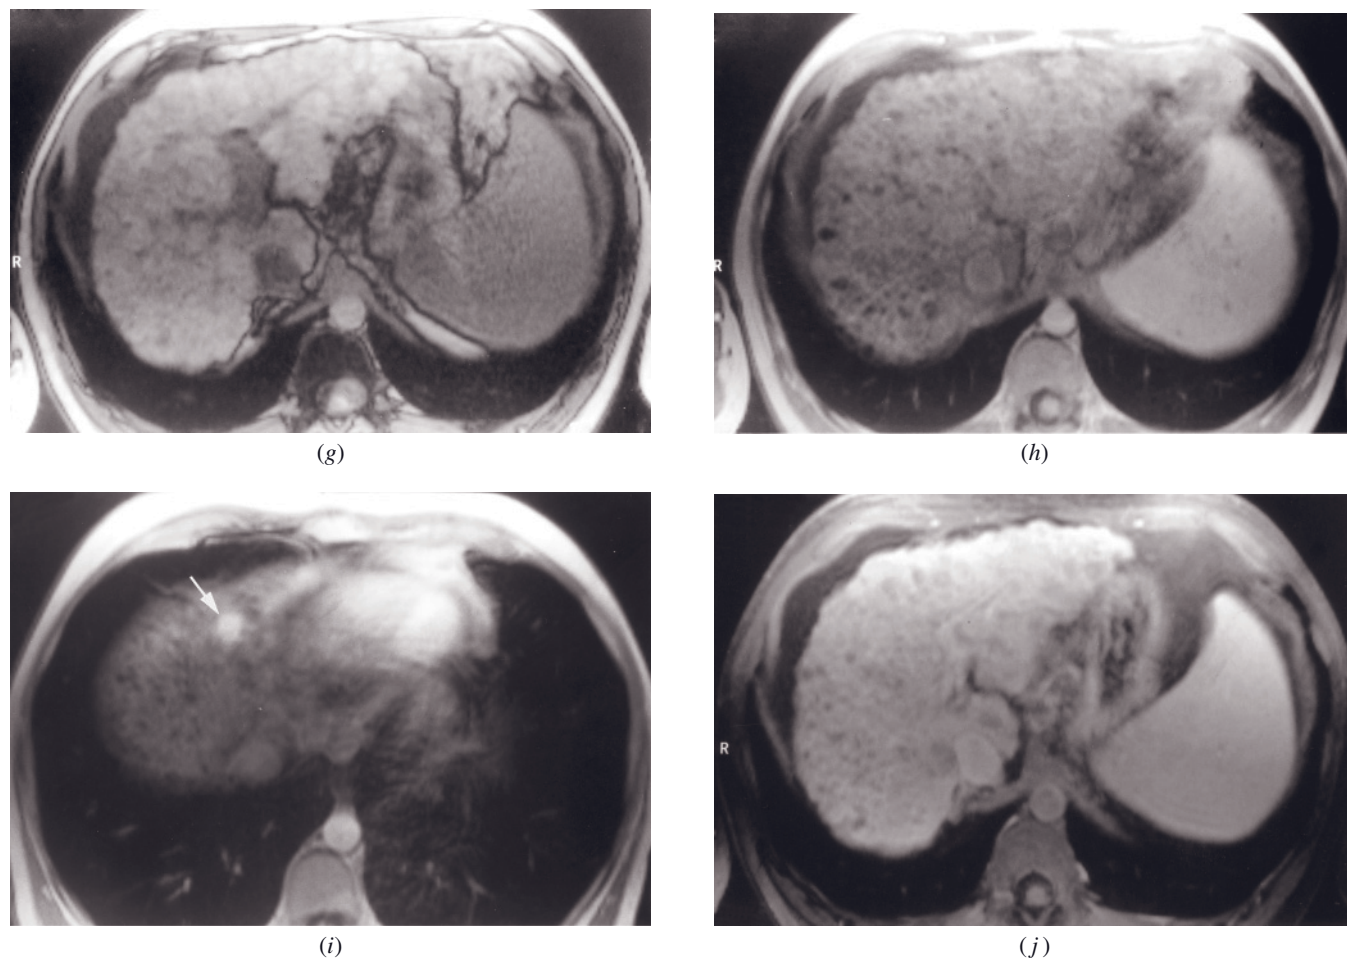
(*Continued*) consistent with cirrhosis. Multiple varying-sized siderotic nodules are appreciated throughout the hepatic parenchyma that demonstrate low signal on both T2-weighted (*a*, *e*) and T1-weighted (*b*, *f*) images and negligible enhancement early (*b*) and late (*j*) after gadolinium administration, compatible with regenerative nodules. In the second patient, an intensely enhancing 1-cm nodule is also shown on early-phase image (arrow, *i*), which fades on late image (not shown) in the dome of the liver, consistent with a high grade dysplastic nodule.
